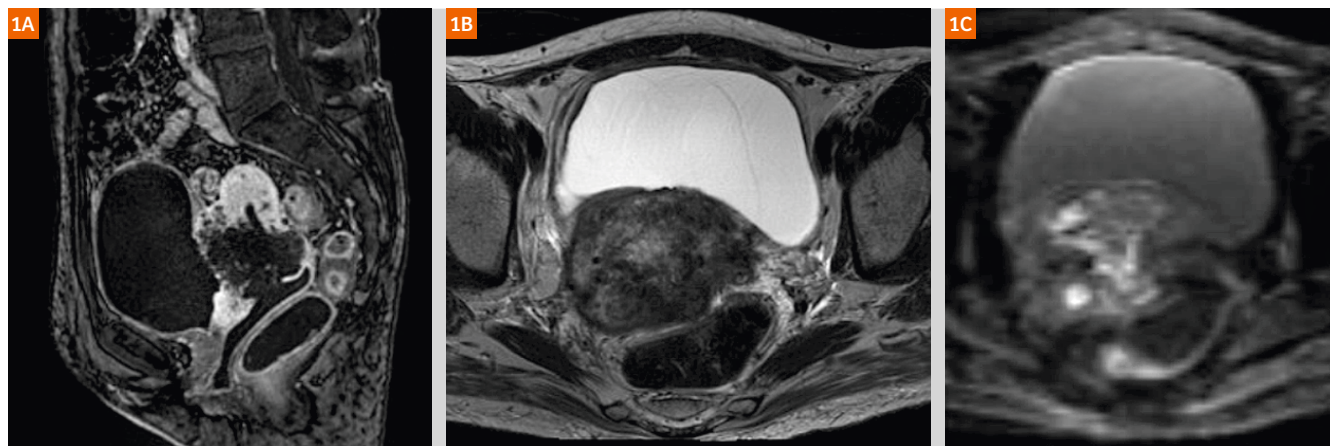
Diagnostic sagittal T1-weighted VIBE post Gd-contrast (1A) of a cervix carcinoma in situ. Transversal T2-weighted image (1B) showing a large tumor with extensive diffusion restriction on transversal TraceW diffusion-weighted image (1C).
